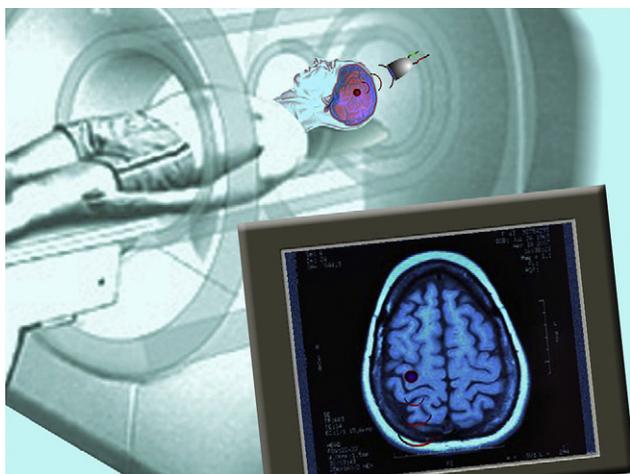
The proposed LIFUP used simultaneously within rtfMRI imaging. Low intensity focused ultrasound pulsation will be sent to a specific point within the brain, targeted by MRI and the responses from the focus and other points in the brain functionally connected to the focus will be monitored by rtfMRI.
